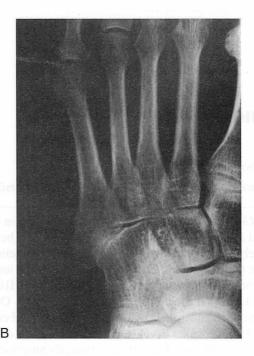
35-year-old man. (A) Radiograph at the time of initial presentation reveals no evidence of osteosclerosis or bone resorption. The fracture is classified as type I. (B) Radiograph at 8 weeks shows bone union.
